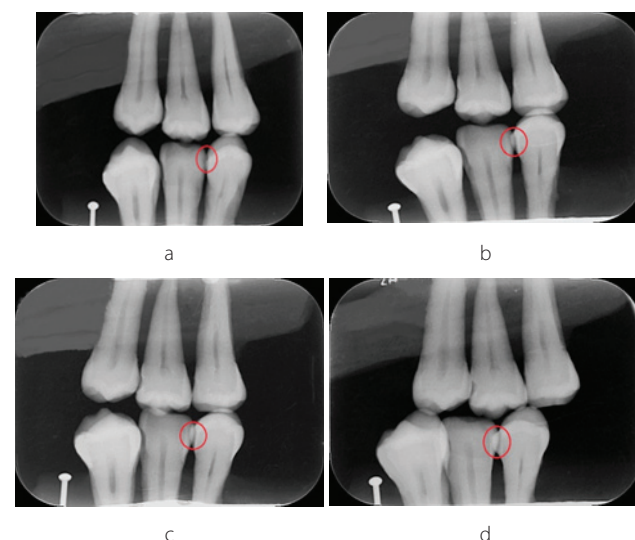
Bitewing radiographs taken at 0° (a), 5° (b), 10° (c) and 15° (d) horizontal angles
